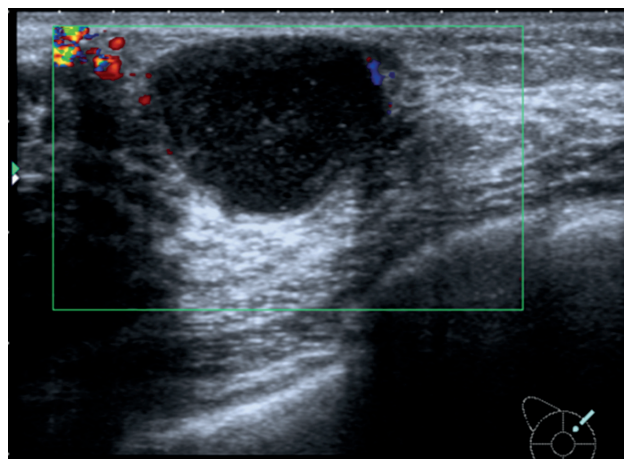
Right breast ultrasound performed on the first episode demonstrating the presence of a fluid filled collection, measuring around 1.66 x3.56 cm located at 1 o'clock.
